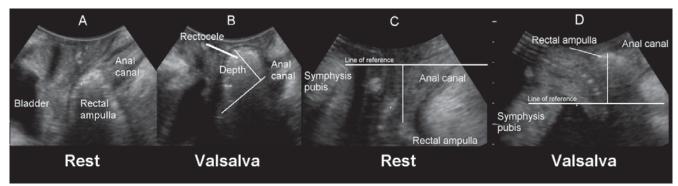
The distinction between a 'true rectocele', i.e., a defect of the rectovaginal septum (shown by the left pair of images) and perineal hypermobility, i.e., descent of the rectal ampulla without fascial defect (right pair of images). Adapted from *Ultrasound Obstet Gynaecol* 2005; 26: 73–77 with permission.
